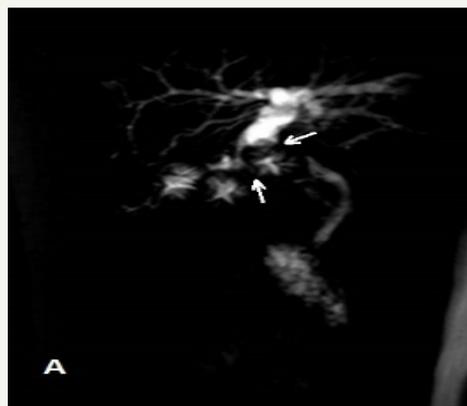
Image of the Cholangio-MRI with image defect due to cholelithiasis, causing a stenosis of the common hepatic duct with retrograde dilatation of the biliary tract.
